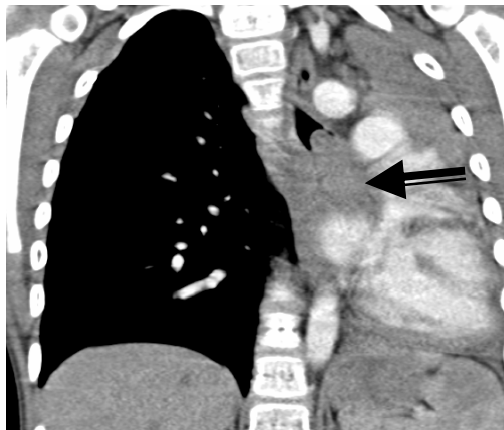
CT scan of chest confirmed a collapsed left lower lobe and a soft tissue mass in the left main bronchus extending into the left lung
